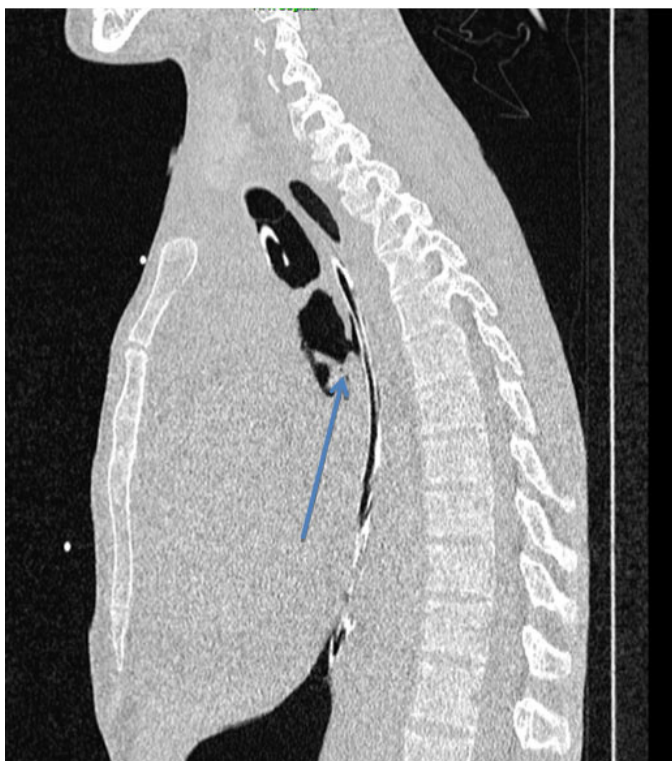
Esotracheal fistula on CT scan reconstruction sections.
